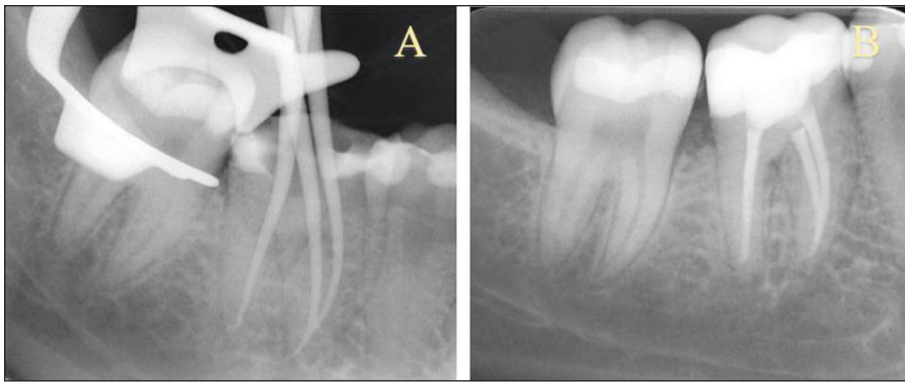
Master cone radiography (A), final radiography (B)
